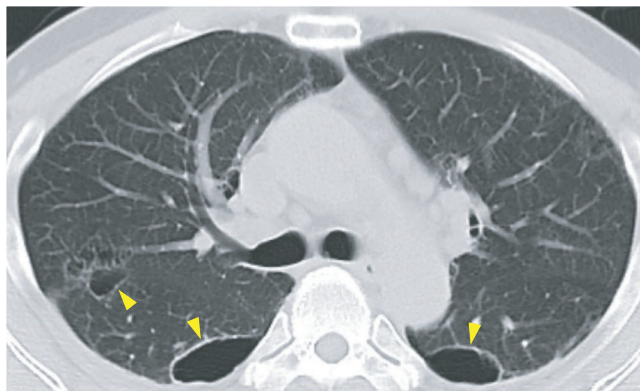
Follow-up CT performed after 48 hours showed air leakages bulging to form a convex shape, indicating that the leakages were inside the pleura (arrowhead)
